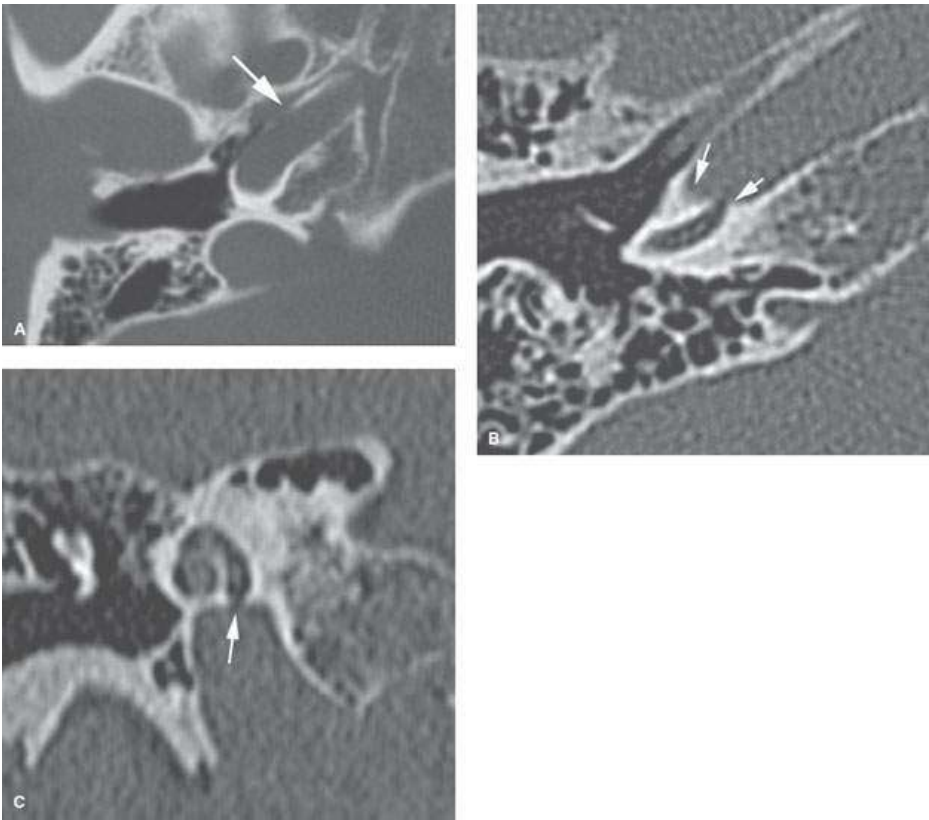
A: Anatomic variant of the carotid canal. Axial computed tomography image showing a focal dehiscence in the bony plate covering the carotid artery. B, C: Dehiscence between the carotid canal and cochlear basal turn that might be a cause of pulse synchronous tinnitus.
